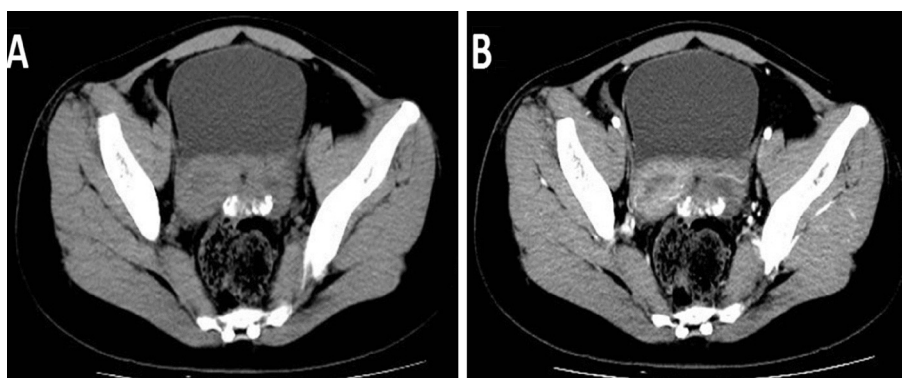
A 22-year-old female with pelvic tuberculosis. Non-enhanced CT scan of the abdomen and pelvis shows a lobulated, ill-defined, left adnexal mixed (solid and cystic) mass with calcification within it (A). Contrast-enhanced CT scan shows heterogeneous enhancement (B).
